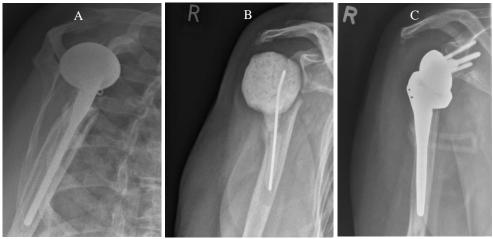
Infected shoulder hemiarthroplasty. (X-ray A) Hemiarthroplasty, axial view, (X-ray B) spacer after infection, (X-ray C) revised by RSA after treatment of infection.
